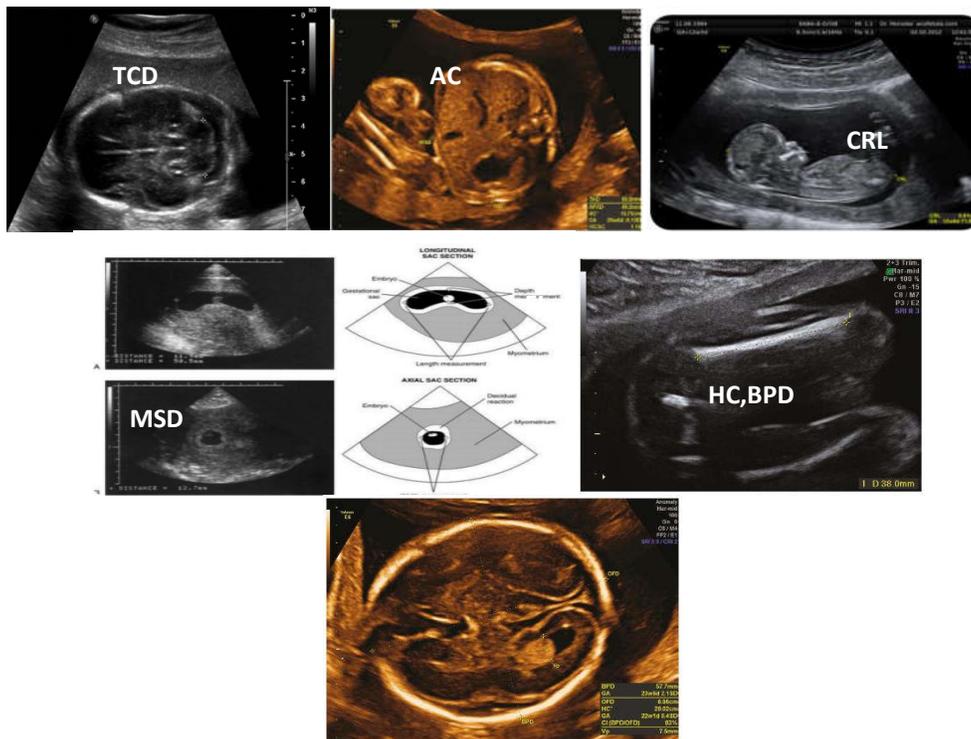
Ultrasound pictures of fetal biometry measurement.
